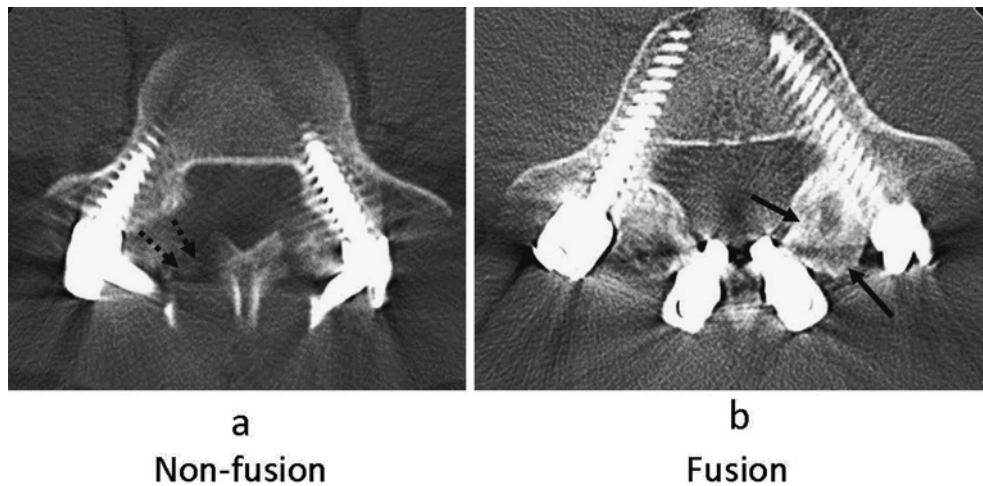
Bone fusion was evaluated by computed tomography. Non-fusion was defined as to be present when trabeculae did not pass across the lytic defect; (a) Fusion was defined as to be present when trabeculae passed across the lytic defect; (b) The dotted arrow shows the location of non-fusion. The black arrow shows the location of fusion.
